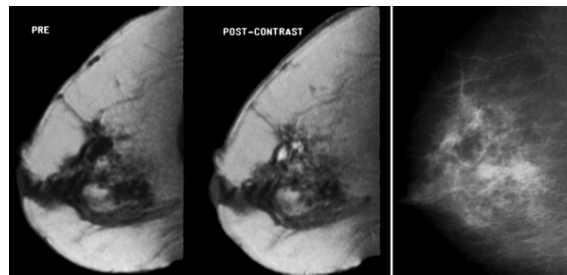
Mammographically occult carcinoma in a dense breast. MRI (left) are obtained before (PRE) and after (POST) gadolinium administration. The white area in the post-contrast image denotes marked enhancement of a centrally located breast carcinoma. A mammogram of the same breast (right) shows dense tissue, but no lesion at the location where the cancer was detected by MRI (Conant and Maidment, 1996).
